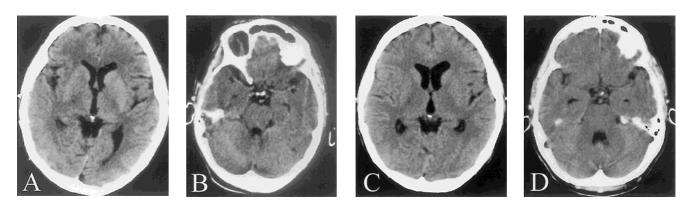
Case 3. Computed tomographic scans of a 41-year-old woman with pneumococcal meningitis. (A) On day of admission (day 1), a first CT scan 3 hours prior to clinical herniation revealed no signs of raised ICP, and no obliteration of the basilar cisterns or other radiological signs of impending cerebral herniation (B). (C) One hour after clinical herniation (4 hours after the first CT scan) mild enlargement of the lateral and third ventricle was evident, but there was no sulcal effacement or other signs of raised ICP. (D) In addition, basilar cisterns were unchanged and not obliterated. A ventriculostomy 5 minutes after the scan revealed an opening pressure of 44 mmHg.
